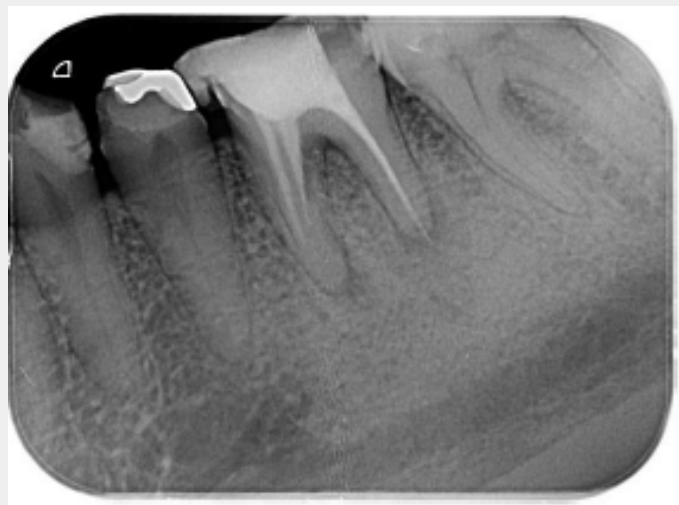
Radiographic evaluation after treatment and root canal filling.
